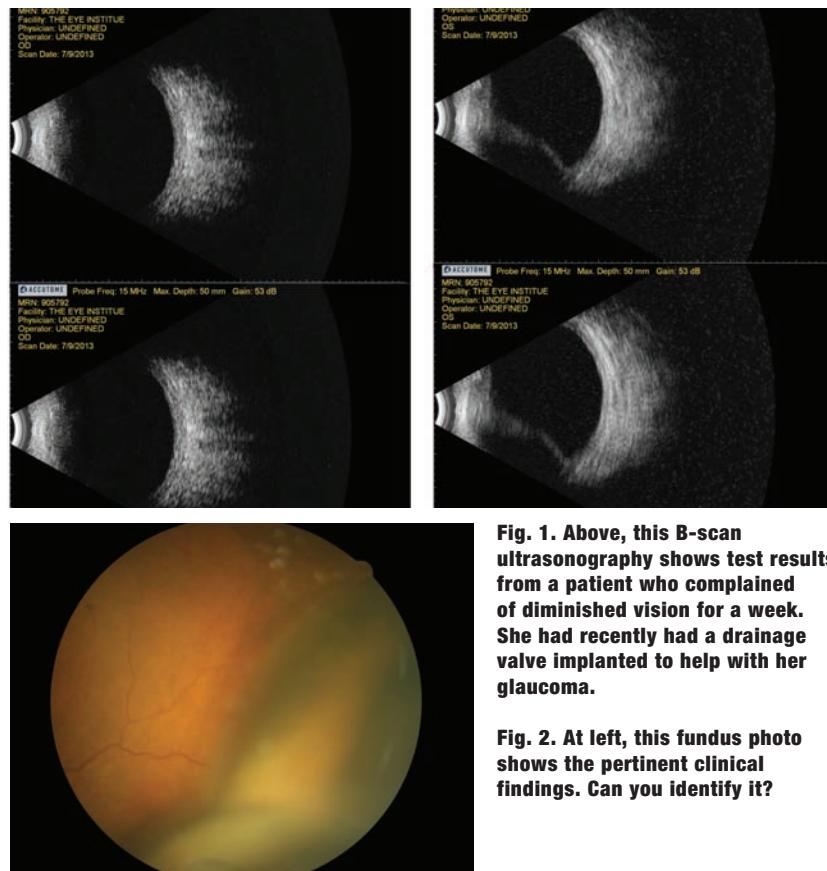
Above, this B-scan ultrasonography shows test results from a patient who complained of diminished vision for a week. She had recently had a drainage valve implanted to help with her glaucoma.
